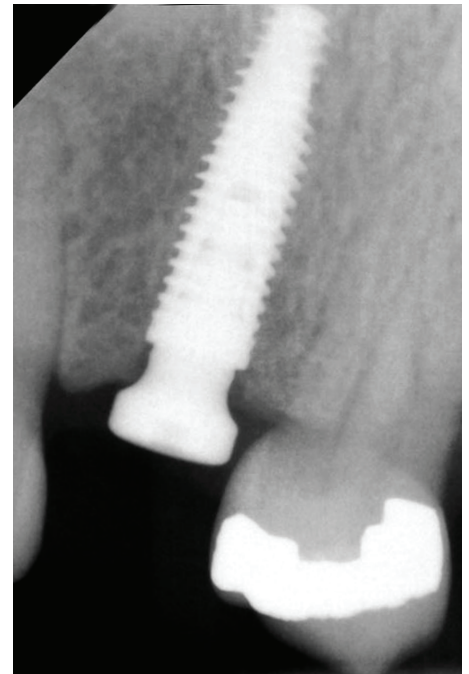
Post placement radiograph of an implant placed into a healed site at the maxillary left 1st premolar.
